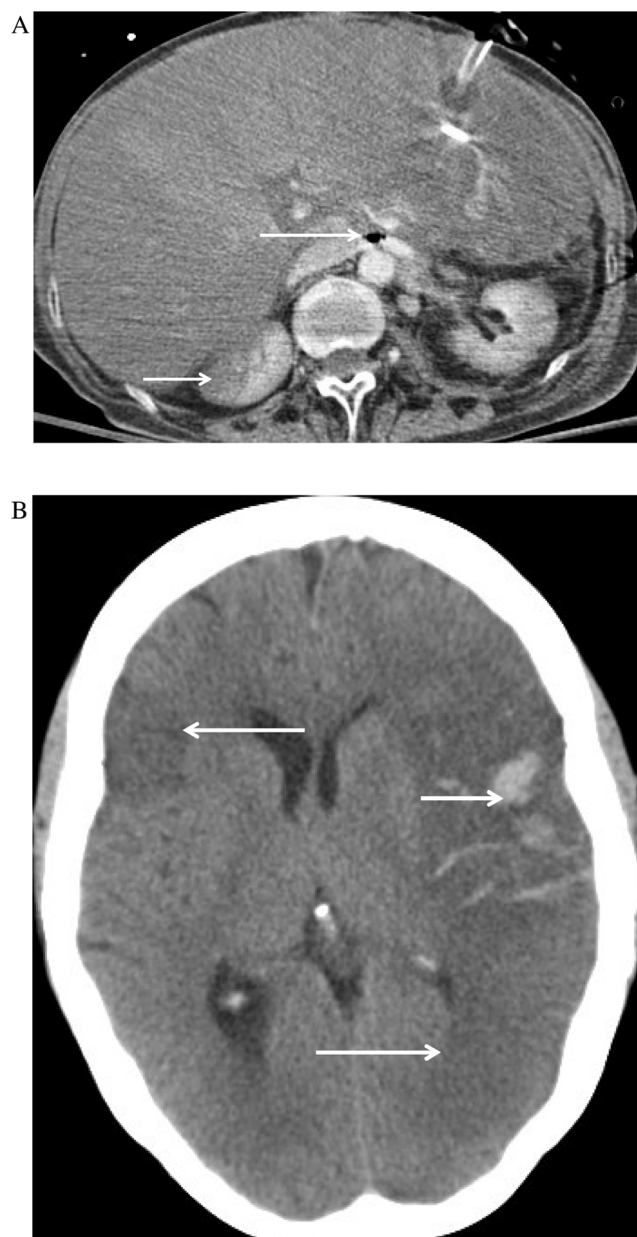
A. CT abdomen at day 165 showing poor enhancement of the liver with heterogeneous attenuation of the right lobe, gas in the left renal vein (long arrow) and infarcts in the right kidney (short arrow). B. CT head at day 165 showing extensive bilateral cerebral infarction (long arrows), left fronto-parietal hemorrhage (short arrow) and mass effect within the left cerebral hemisphere.
